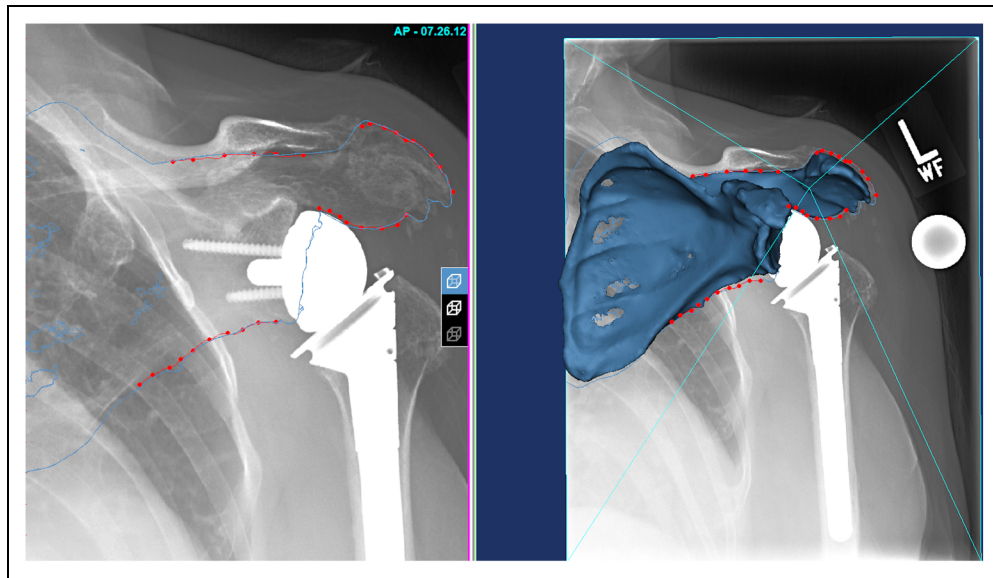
Radiograph registration to 3D CT. Radiographs were registered to calculate post-operative position of glenoid baseplate within pre-operative 3D CT of scapula.
